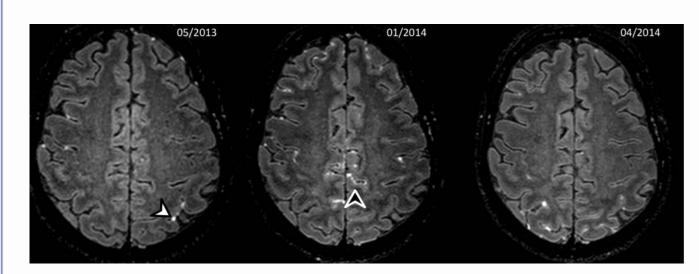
1-year follow-up 3D-FLAIR post-contrast MR images in an axial plane showing a dissociated evolution of the leptomeningeal contrast-enhancements in a patient with a SS. Sequential MRIs show disappearance of the left parietal LME (white arrowhead ≥) and onset of new LME (black arrowhead ≥), both of them disappearing later in April 2014.
